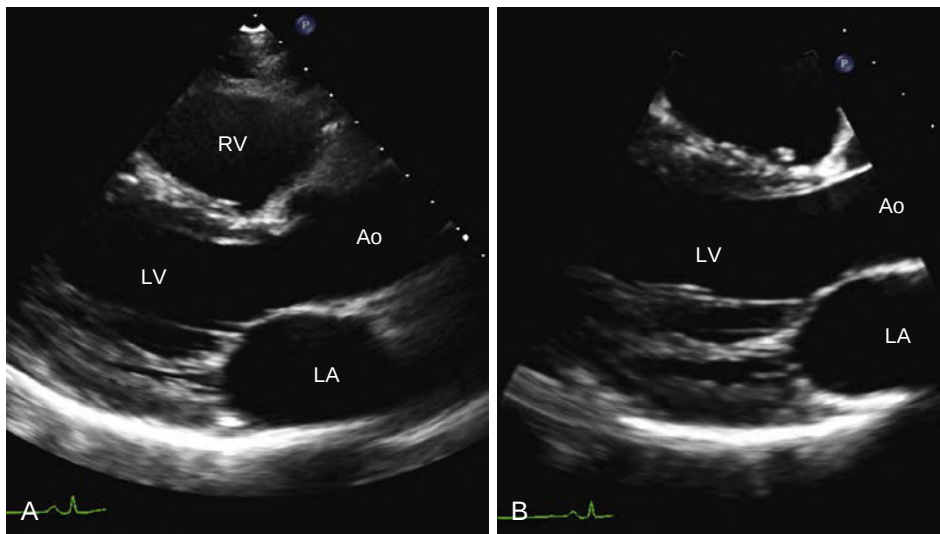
Mitral valve imaging. (A) First the mitral valve is examined at a standard depth in the parasternal long-axis view. (B) Then zoom mode (ZOOM) is used to optimize visualization of the aortic and mitral valves. The image plane is angled slightly medial and lateral to encompass the medial and lateral aspects of the valve. Some normal thin mitral chords are well seen in this slightly laterally angulated view, extending from the mitral closure plane to the papillary muscle.
